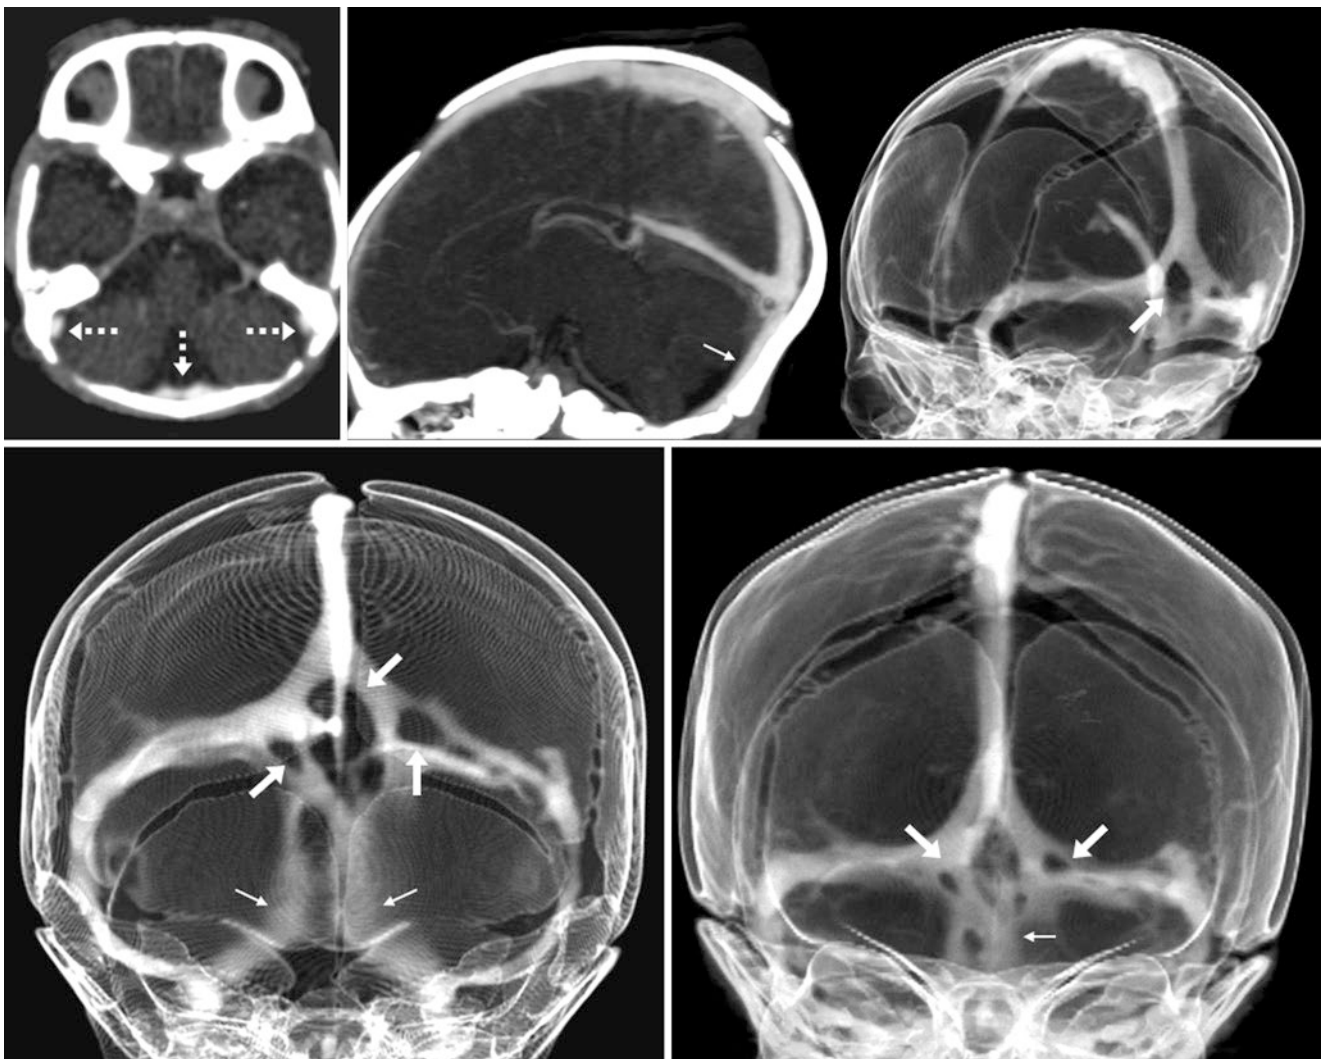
Dorsal SSS multiple fenestrations. A 1-day-old neonate had diffusely dense dural sinuses on nonenhanced CT (*dotted arrows, top left*), raising the question of thrombosis. However, a CTV showed patent sinuses on a sagittal MPR (*top middle*) and on “see through
